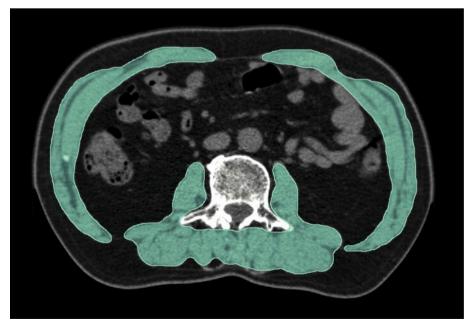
Cross-sectional areas of skeletal muscles in the third lumbar vertebrae level are measured by manual outlining on an axial CT image (highlighted in cyan) for assessing the presence or absence of sarcopenia.
